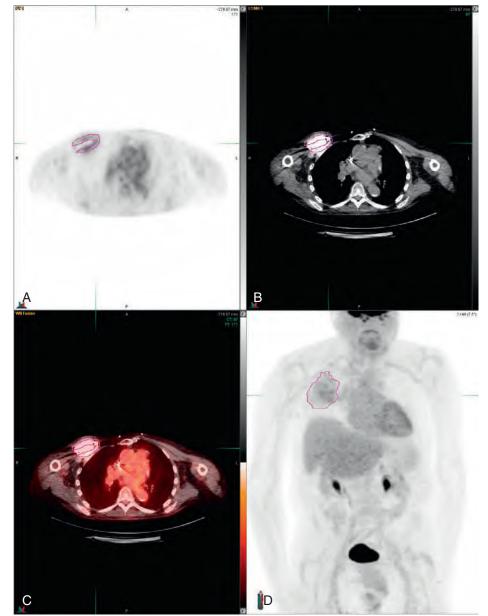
Increased fluorodeoxyglucose activity at cardiovascular implantable electronic device generator pocket consistent with device infection. (A) Axial positron emission tomography. (B) Axial computed tomography. (C) Maximum intensity projection image. (D) Fused images. (Copyright Mayo Clinic.)
